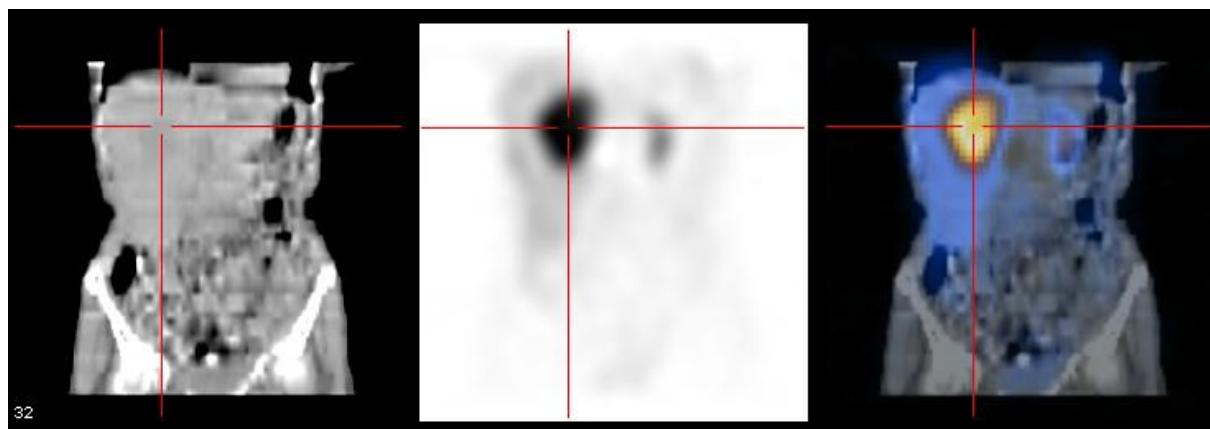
SPECT/CT images of neuroendocrine tumor (VIPoma) in the liver. CT (left), somatostatin receptor scintigraphy with ^{111}In -Octreotide (center) and fused SPECT/CT images (right).
